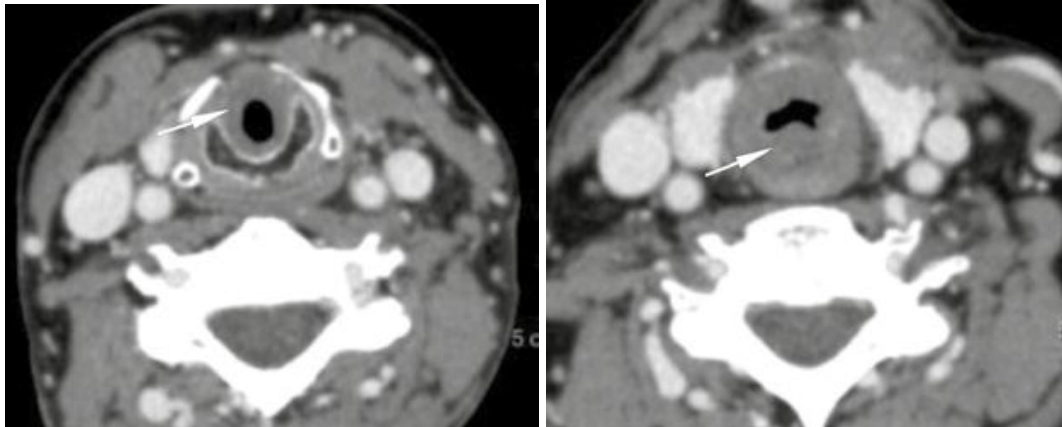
Computed tomography of the neck, post-contrast examination, axial scans (A, B): circular infiltration of the larynx and trachea (arrows) with narrowing of the lumen. Lack of visualization of regional enlarged and altered lymph node density.
